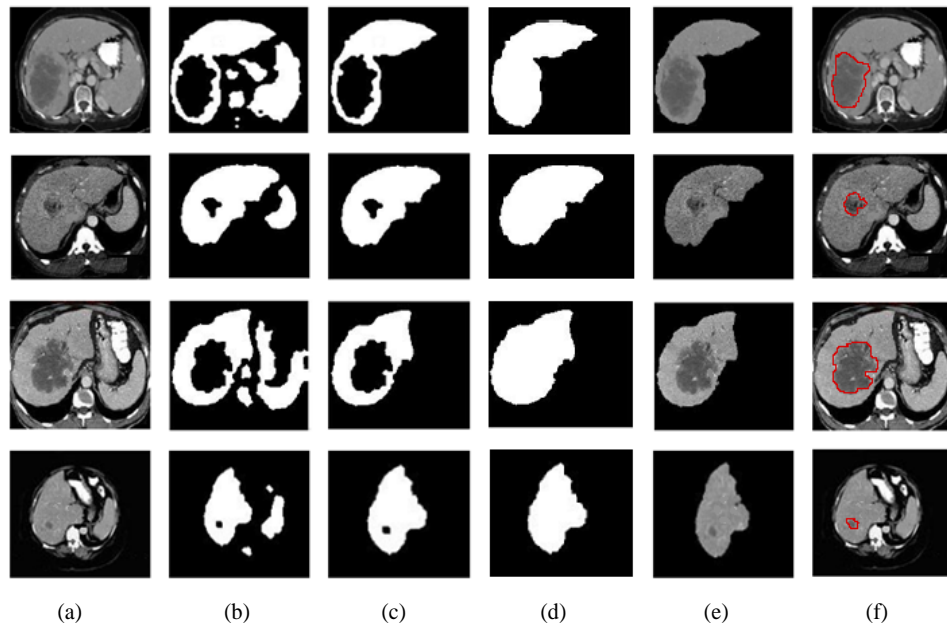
Results of Liver Tumor Segmentation on the CT Image (a) Abdominal CT Image (b) Morphological Processing (c) Largest Area Component (d) Hole filling (e) Segmented Liver (f) Segmented Liver Tumor
